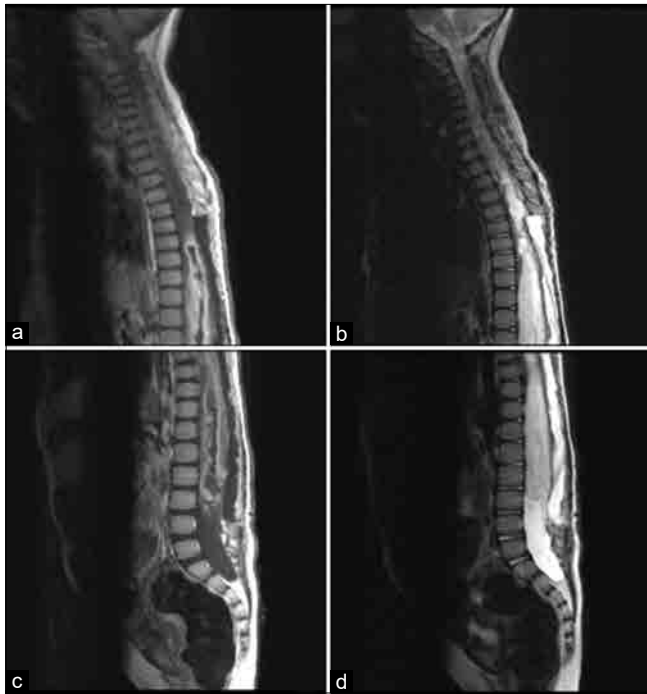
T1 postcontrast thoracic (a) and lumbar (b) and T2 noncontrast thoracic (c) and lumbar (d) sagittal midline views of patient's postoperative MRI demonstrate an expansile, intramedullary astrocytoma extending from T7 to L3 is demonstrated with associated syringohydromyelia extending from C2 to T7 with a remodeled and expanded spinal canal after decompressive laminectomies were performed from T7 to L3.
